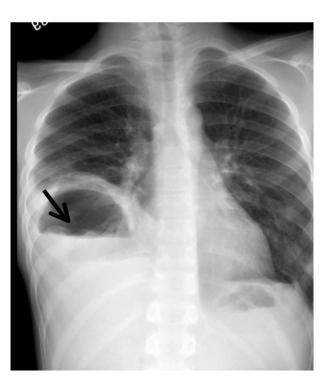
AP view X-ray of the chest showing large right lower lung lobe cavitary lesion with an irregular wavy internal air—fluid level (long arrow) giving the appearance of the water lily sign.
